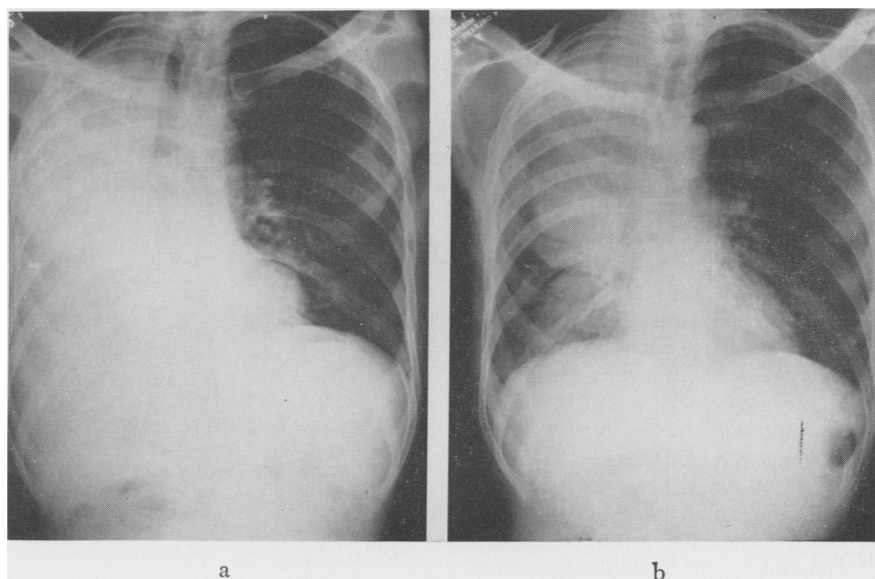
Roentgenograms of the chest in Case 4, (a) before, and (b) after perfusion.
